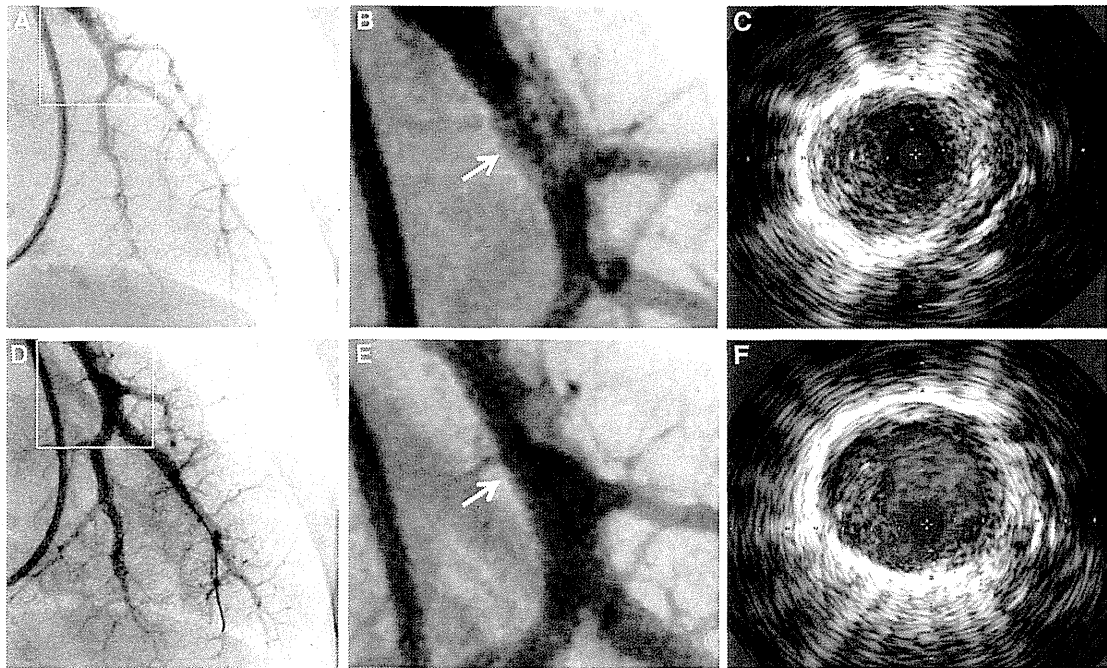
Representative angiographic and intravascular ultrasound (IVUS) images of balloon pulmonary angioplasty (BPA). A, Site of an intravascular web of the left pulmonary artery is indicated with a square on the angiogram. Peripheral arteries have shrunk because of a reduction in blood flow. B, A magnified image of a square in Figure 1A. An intravascular web is indicated with arrows. C, IVUS image (at the arrow in Figure 1B) shows organized thrombi, which occupy the lumen, and blood flow is limited in small channels. D, After a 5-mm balloon is dilated at 8 atm, an angiogram shows a dilated vessel and increased flow in the distal arteries after BPA. E, A magnified image of an intravascular web shown in Figure 1D. An intravascular web indicated with arrows is compressed and a vessel diameter of the distal artery is increased. F, IVUS image (at the arrow in Figure 1E). Thrombi are forced to 1 side and the lumen size is enlarged.
